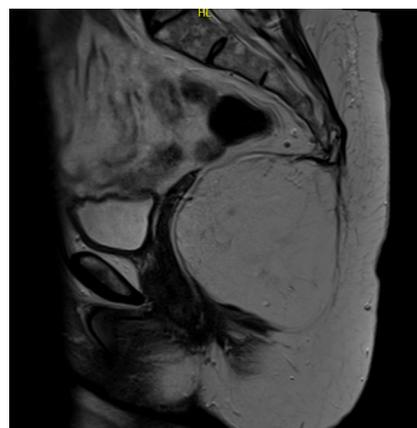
Preoperative MRI (sagittal slice) demonstrating a right perirectal mass measuring 9.3×8.6×10 cm. The mass is tethered to the coccygeal tip.
